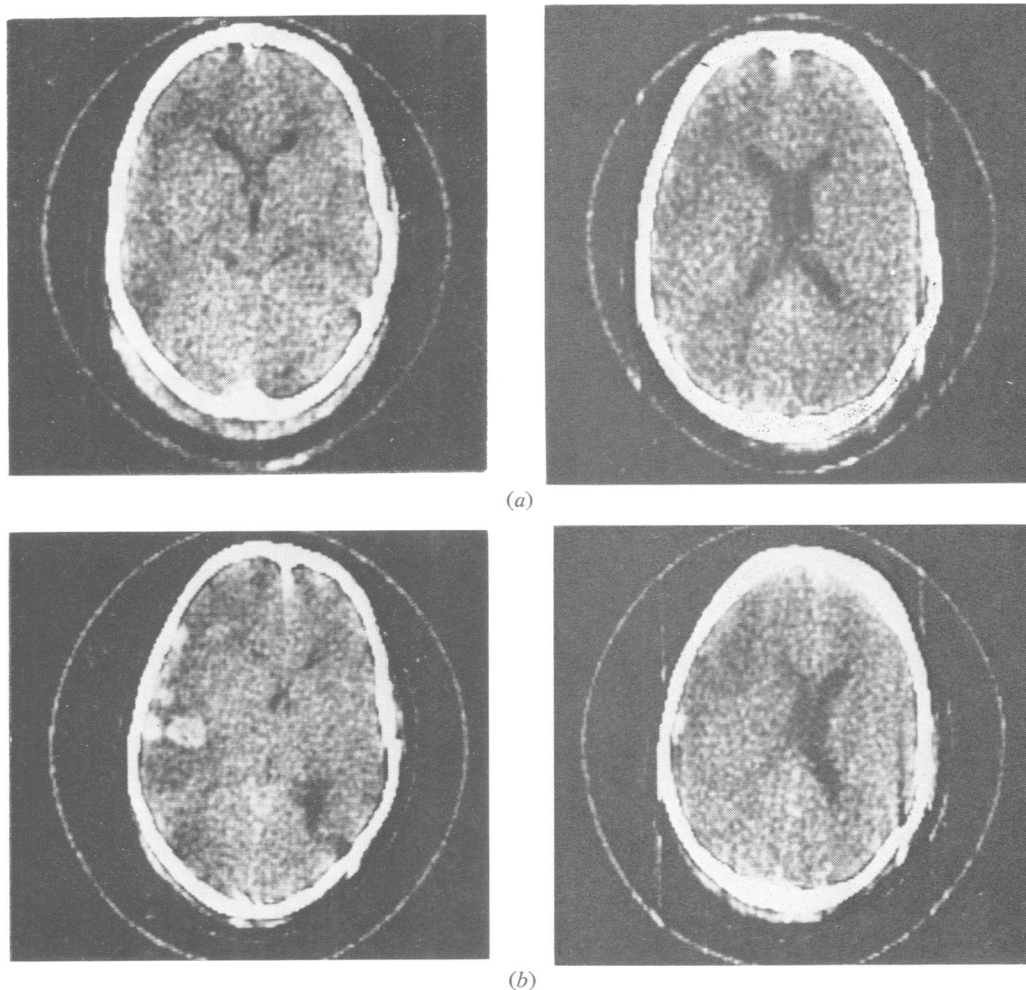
(a) CAT scan two and a half hours after injury. There is no shift of the ventricles. An area of mixed reduced and increased density in the left frontoparietal area is suggestive of contusion. (b) CAT scan 24 hours after injury. There is now marked displacement of the ventricles to the right, contusions are obvious and these amount to an intracerebral haematoma in the left posterior frontal region. JMCS, aged 5 years. Fell out of a fourth floor window. He was unconscious on admission, reacting to painful stimuli by abnormal flexion of limbs. Radiography revealed a right parieto-occipital fracture. The patient's condition improved to the state where he was localising to pain, but the next day he started having apnoeic attacks. After the repeat CAT scan, craniotomy revealed a left frontal intracerebral haematoma, and a left frontal lobectomy was performed. No material improvement after operation, died four days after the accident.
